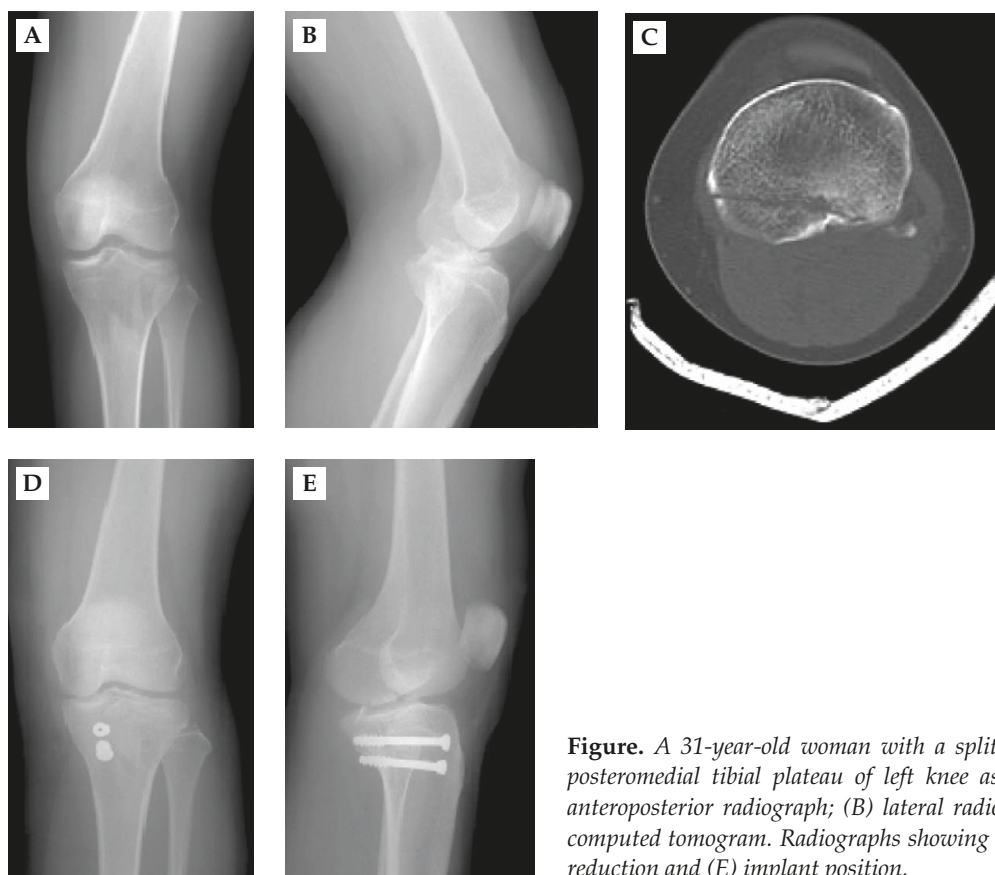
A 31-year-old woman with a split fracture of the posteromedial tibial plateau of left knee as shown in (A) anteroposterior radiograph; (B) lateral radiograph; and (C) computed tomogram. Radiographs showing (D) the fracture reduction and (E) implant position.
